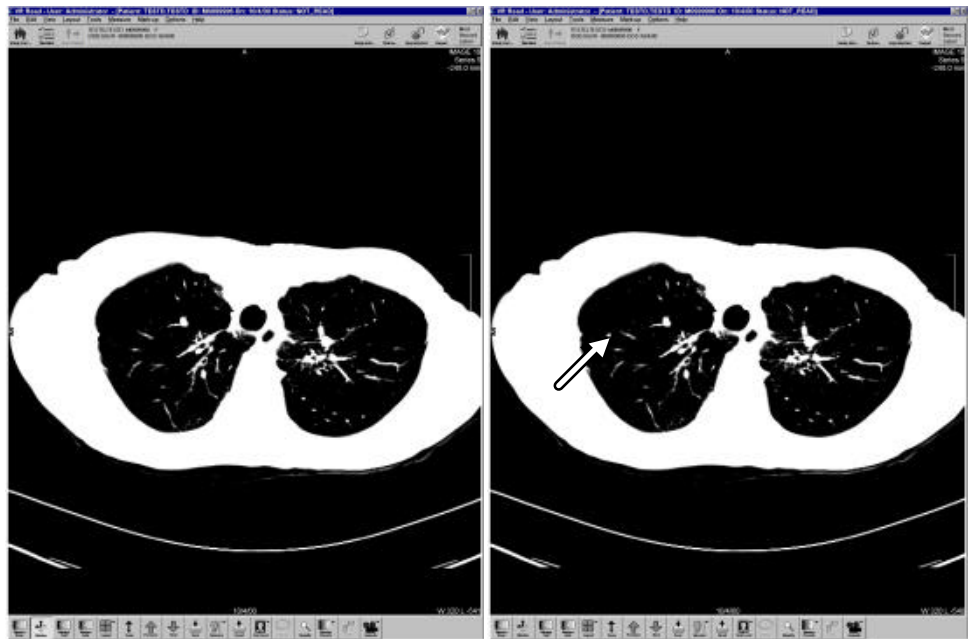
(a) A CT chest, (b) Same CT with an artificial lesion inserted (arrow). (Courtesy of Michael Zhou)
